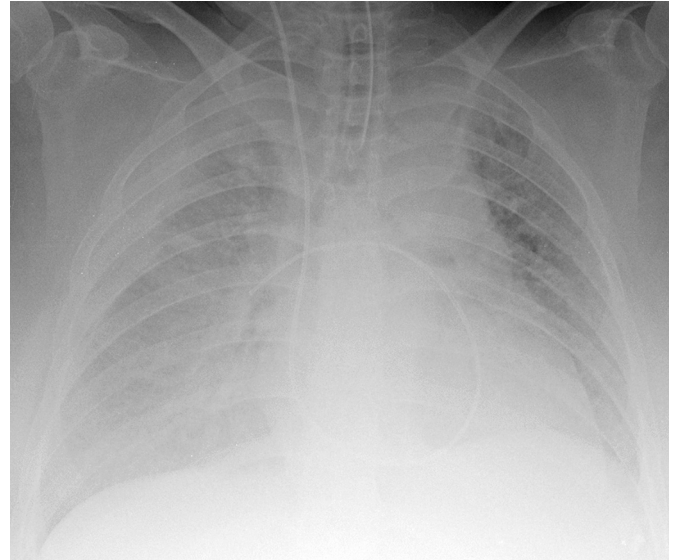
Chest radiograph showing pulmonary oedema after institution of *i.v.* prostanoid treatment.
